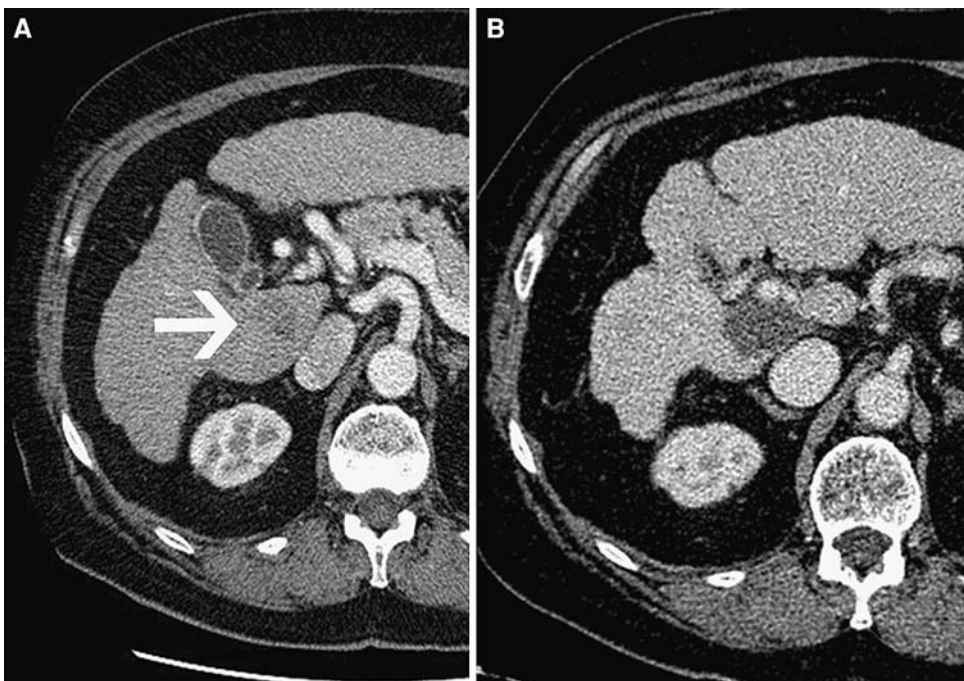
(A) Pre-treatment contrast-enhanced CT demonstrates a cirrhotic liver with a caudate lobe (segment 1) hepatoma (arrow). (B) At 2-year imaging follow-up, contrast-enhanced CT scan demonstrates not only complete necrosis and avascularity of the radioembolized segment 1 hepatoma, but an increase in the size of the lesion. Using traditional size criteria this lesion would be considered stable disease as opposed to complete response by necrosis criteria.
